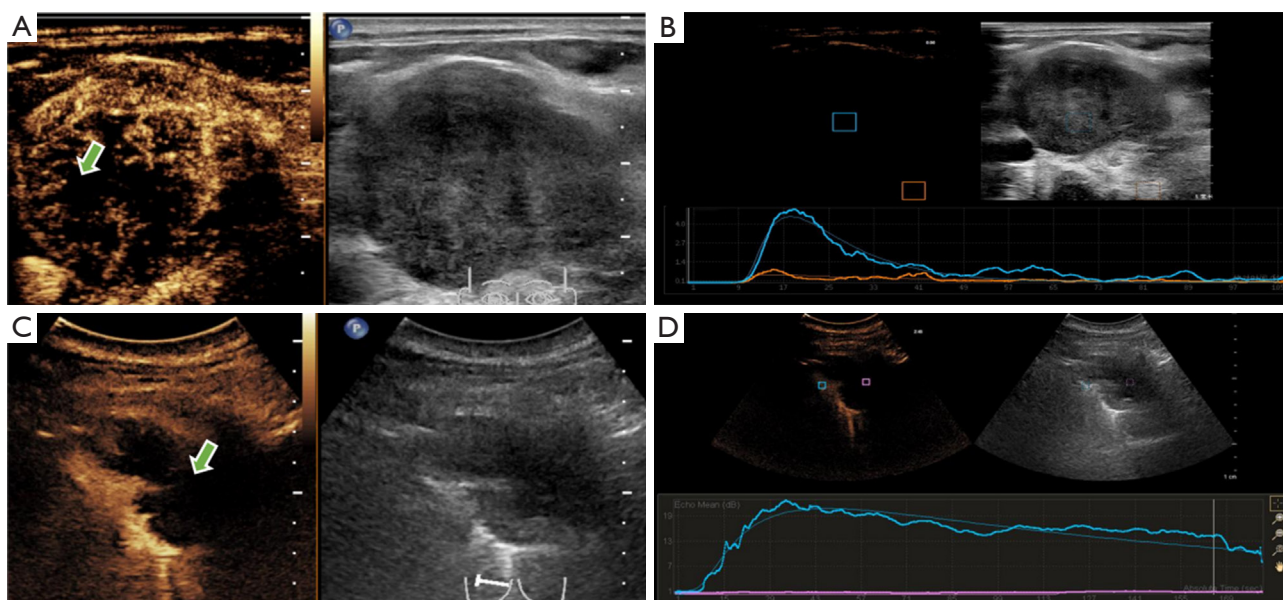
CEUS images of cervical lymph nodes and mediastinal masses. (A) CEUS and US images of the right cervical enlarged lymph node at the peak at 18 s, with a restricted non-enhancing area inside (green arrow). (B) Peak-intensity curve of CEUS of the enlarged lymph node in the right neck. Blue line: an enhanced area within the lymph node; orange line: surrounding normal soft tissue. (C) CEUS and US images of the posterior mediastinal mass at the peak at 46 s, with a large area of no enhancement seen inside (green arrow). (D) Peak-intensity curve of CEUS of posterior mediastinal mass. Blue line: solid enhancing area around the tumor; pink line: no enhancing area inside the tumor. CEUS, contrast-enhanced ultrasound; US, ultrasound.
